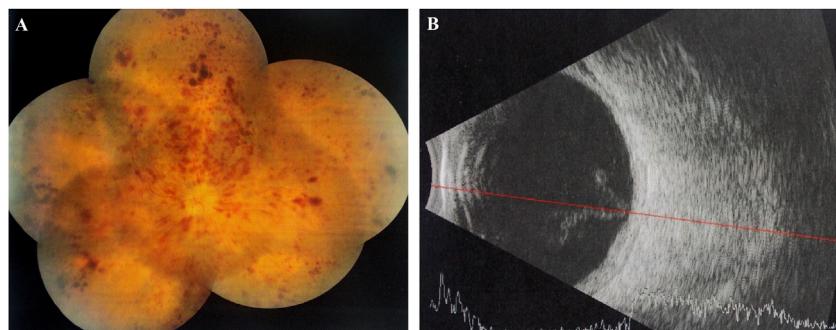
Fundoscopy evaluation after radiosurgery of the right eye showing diffuse splinter and blot hemorrhage extended into all quadrants of the retina. (A) Ultrasonography image revealed decrease in thickness due to partial response of the tumor (B).
